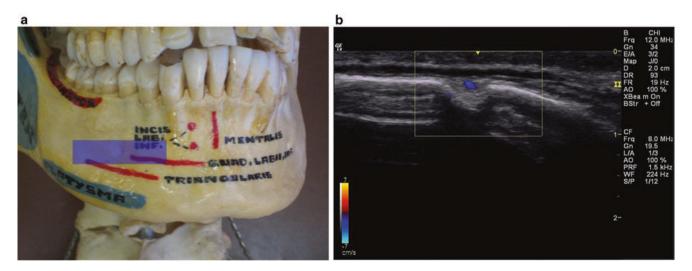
Scanning technique for mental nerve injection (a) Transverse (axial) position of the transducer (semitransparent color rectangle), (b) Doppler mode identifying vessel
